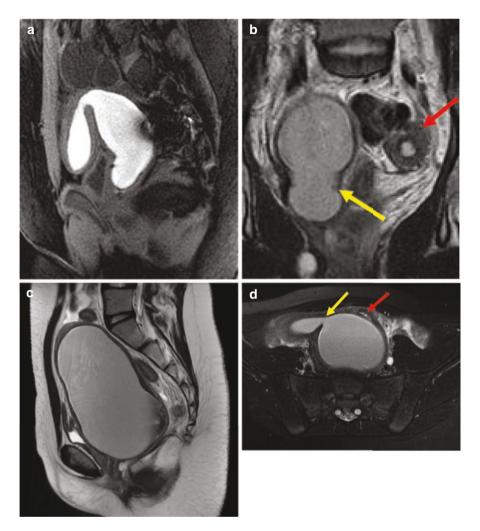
(a) Sagittal T2-weighted MRI image showing obstructed hemivagina with hematocolpos, hematometra, and distended but well-defined cervix. (b) Coronal T2-weighted MRI image showing right hematometra and hematocolpos (yellow arrow) with left uterine horn cross section with normal endometrium (red arrow). (c) Sagittal T2-weighted MRI image of large obstructed hemivagina. (d) Axial T2-weighted MRI image showing distended right hemivagina with hematometra with well-defined right cervix (yellow arrow) and compressed left hemivagina adjacent to distended right hemivagina (red arrow). (Images from Samantha M. Pfeifer MD)
